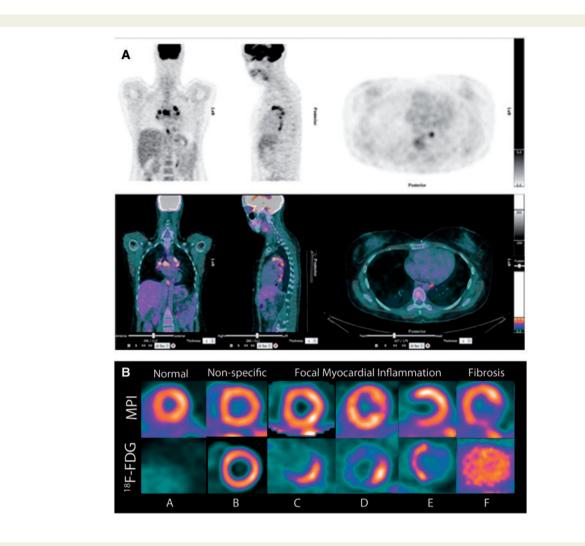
(A) Example of FDG and myocardial perfusion PET in sarcoidosis. The whole body hybrid FDG PET/CT study (A) showed multiple foci of inflammation in the mediastinum, but no active inflammation in the myocardium; hybrid imaging confirms regions of FDG uptake in the mediastinal lymphnodes and not the myocardium. Assessment of systemic disease activity is an advantage of FDG PET compared with echocardiography or CMR. (*B*) Patterns of myocardial perfusion imaging (MPI) and FDG imaging of myocardial inflammation. This figure shows rest MPI in the top row and FDG imaging of myocardial inflammation in the bottom row. A pattern of no myocardial FDG uptake is normal if MPI is normal (A), or fibrosis when MPI is abnormal (*F*, the pattern of FDG uptake represents blood pool activity). A pattern of diffuse myocardial FDG uptake represents a non-specific finding that may be seen with incomplete suppression of physiological myocardial glucose utilization and is not diagnostic for cardiac sarcoidosis (B). A pattern of focal myocardial FDG uptake is consistent with active myocardial inflammation without (*C*, *D*, no perfusion defect) or with coexistent fibrosis (*E*, perfusion defect). Of note, Pattern C, isolated focal FDG uptake in the basal lateral wall in the absence of a perfusion defect, abnormal wall motion, or delayed enhancement on CMR may have reduced specificity for active myocardial inflammation.
